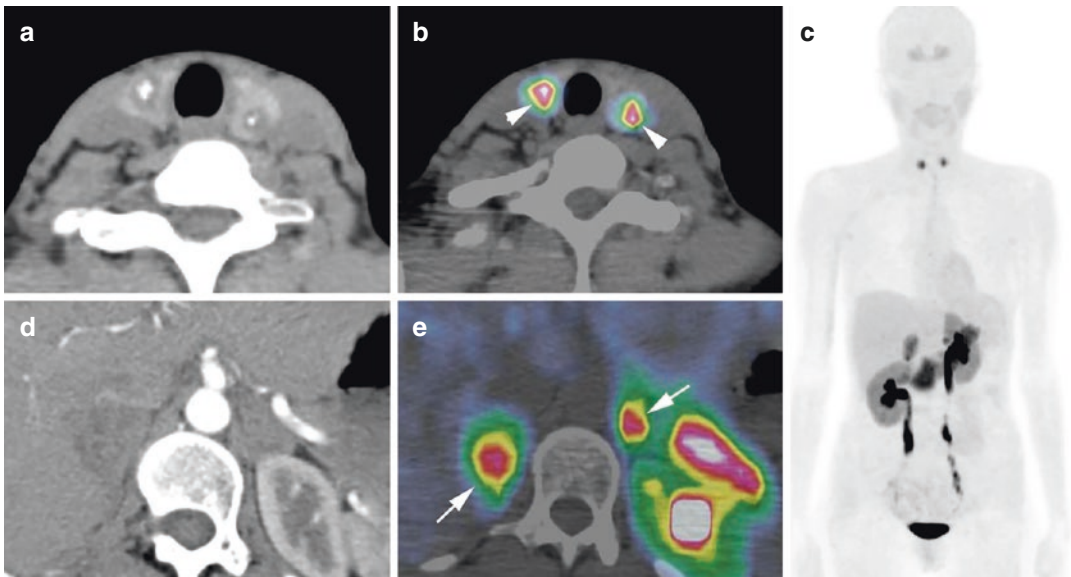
^{18}F -FDOPA PET at initial diagnosis of MTC in a MEN2 patient. ^{18}F -FDOPA PET/CT shows a bilateral MTC (a–c, arrowheads) and a bilateral pheochromocytoma (c–e, arrows)
